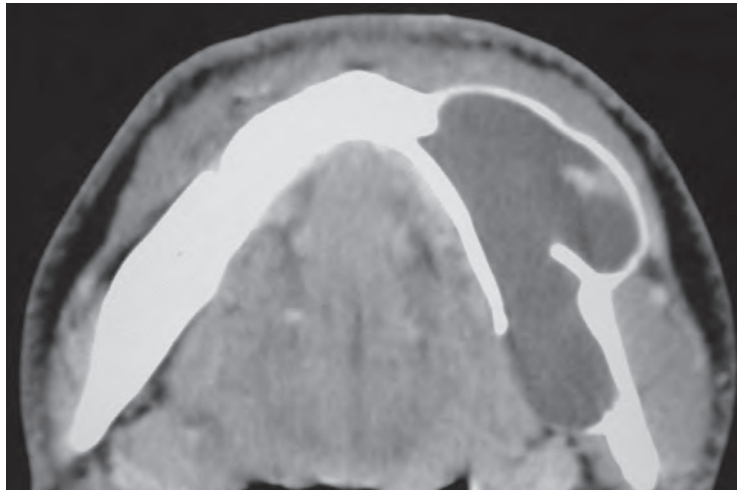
A soft-tissue window of an axial computed tomography scan through the upper alveolus demonstrating a hypodense, expansile, bone-destructive lesion.
